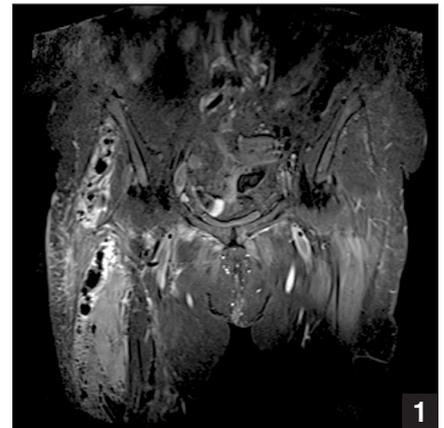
Short tau inversion recovery sequence magnetic resonance image of the pelvis revealing subcutaneous emphysema and increased signal in the thigh musculature, gluteal musculature on the right side, and increased signal along the fascial planes, signs of an advanced necrotizing soft tissue infection.
